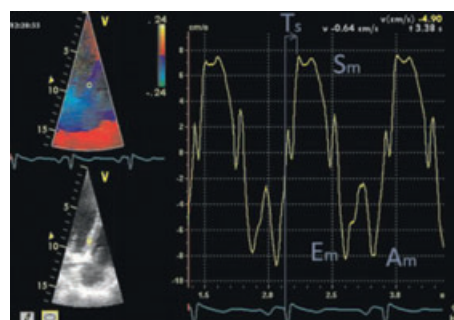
Echocardiographic analysis of tissue velocities using color-coded tissue Doppler.
